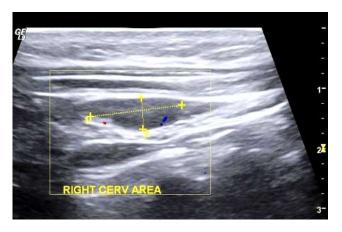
Ultrasound of the neck showing an oval shaped hypo-echoic cervical lymph node.
